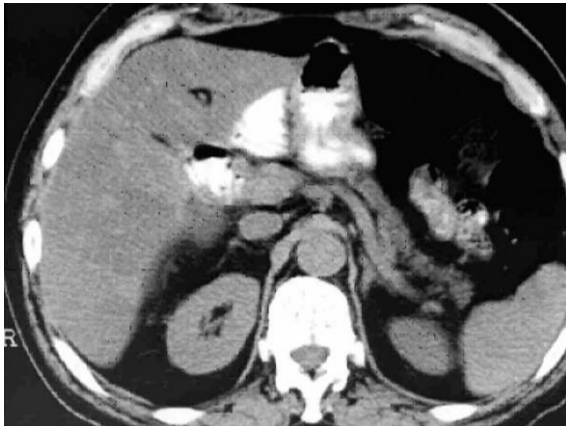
Pancreato-gastric anastomosis after Whipple procedure: normal CT appearance
